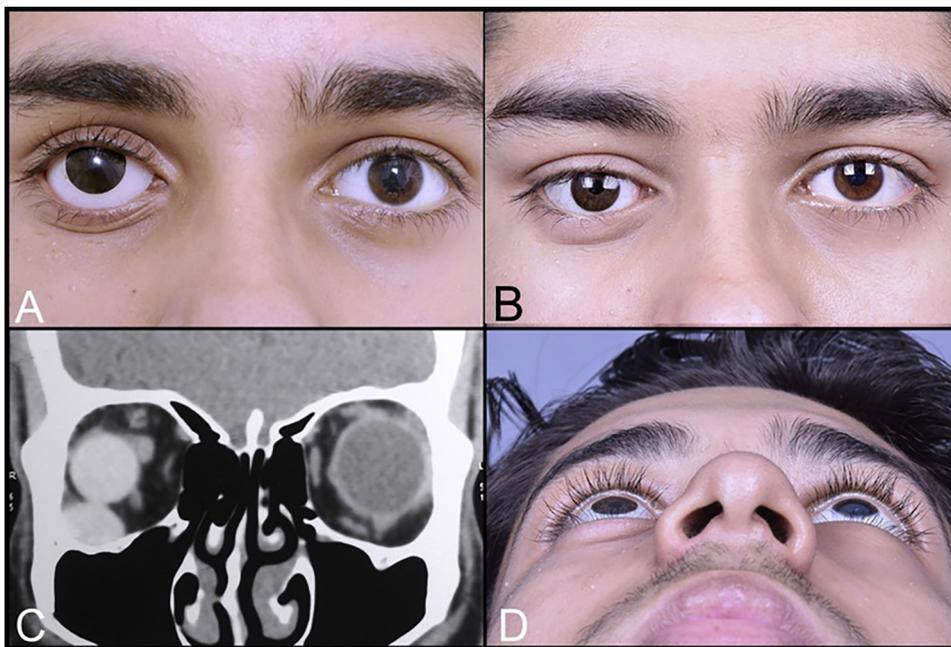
Comparison of pre and post-operative result. A: pre-operative standard view photograph of the patient with superior sulcus deformity and decentered ocular prosthesis, B: post-operative standard view photograph of the patient with correction of the superior sulcus deformity and a better fitting ocular prosthesis. C: post-operative CT orbit of the patient showing an inferotemporal implant pushing the spherical implant towards the central intraconal space. D: post-operative birds view showing adequate orbital volume correction with both the implants in place.
